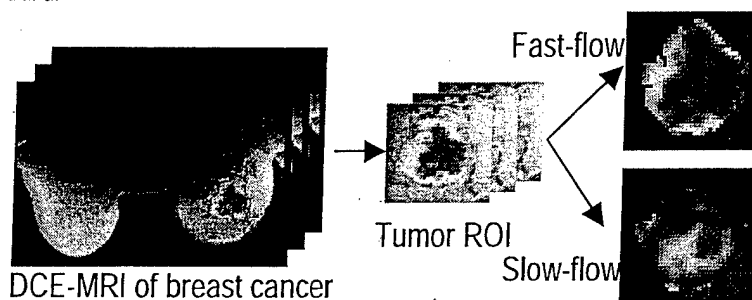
Images of advanced breast tumor obtained by DCE-MRI, where tumor-induced microvascular permeabilities, associated with different perfusion rate, reveal interesting spatial heterogeneous patterns.
